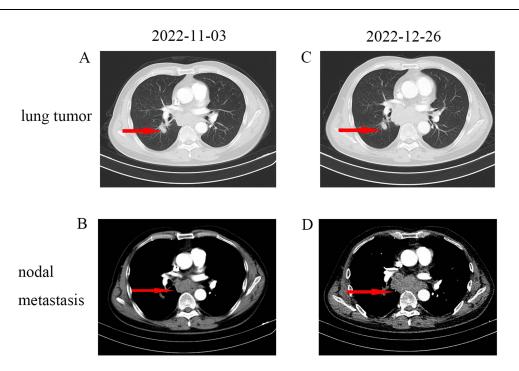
(A and B) Lung mass and nodal metastasis were evaluated as PD compared with CT (12 October 2022). The red arrow in figure A indicates tumors and the red arrow in figure B indicates lymph nodes. (C and D) The lung mass achieved SD, and nodal metastasis achieved PD after two cycles of etoposide combined with cisplatin. The red arrow in figure C indicates tumors and the red arrow in figure D indicates lymph nodes. Abbreviations: PD, progressive disease; SD, stable disease; CT, computed tomography.
